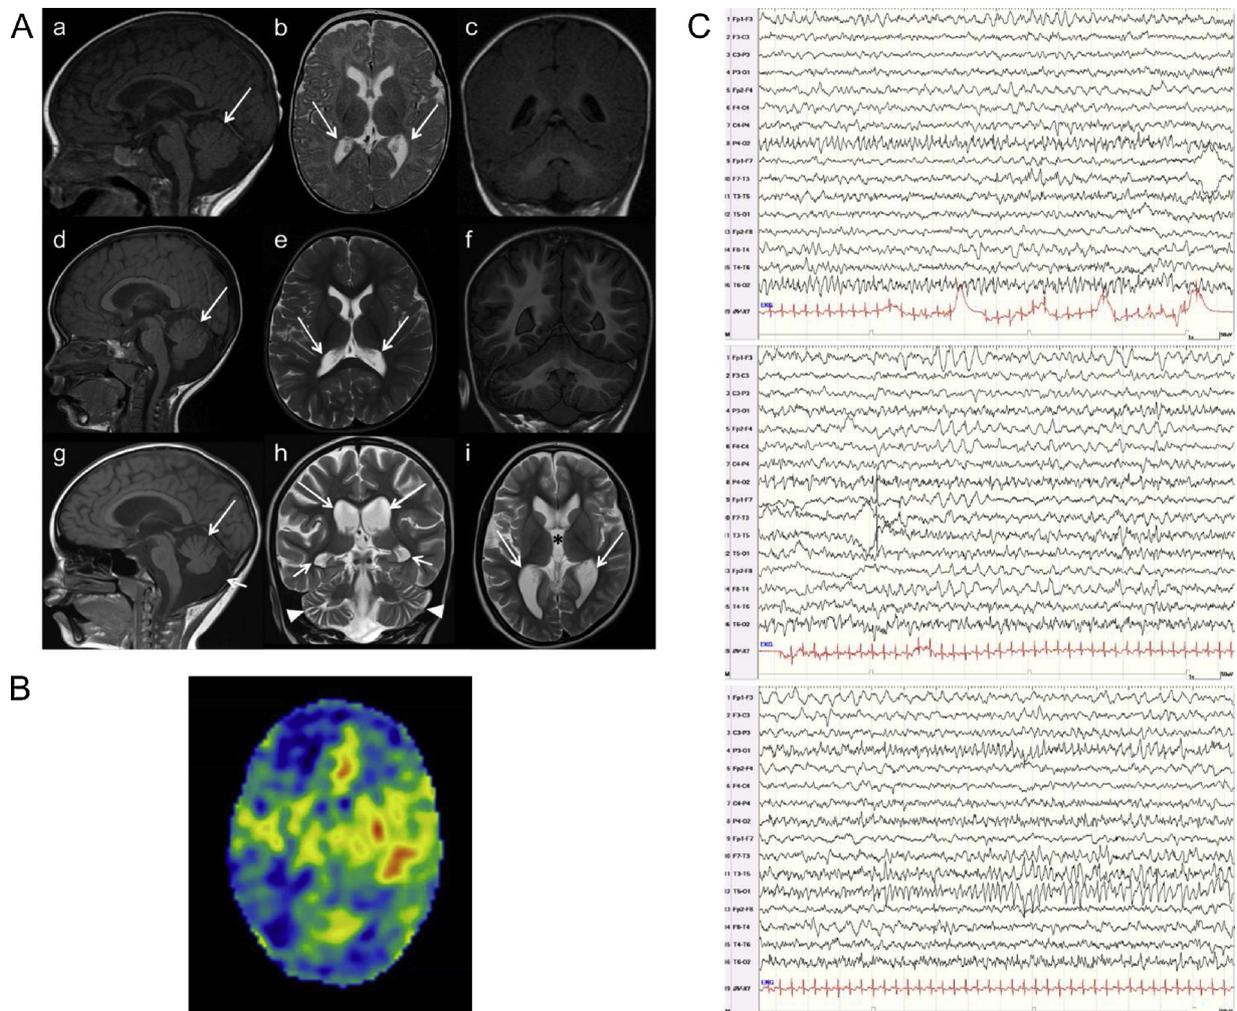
Brain MRI findings of the patient 1 with the *GABRG2* p.P282T variant (Aa-i). Arterial spin labelling (ASL) (B) and video EEG findings (C) of the patient 2 with the *GABRG2* p.S306F variant.
